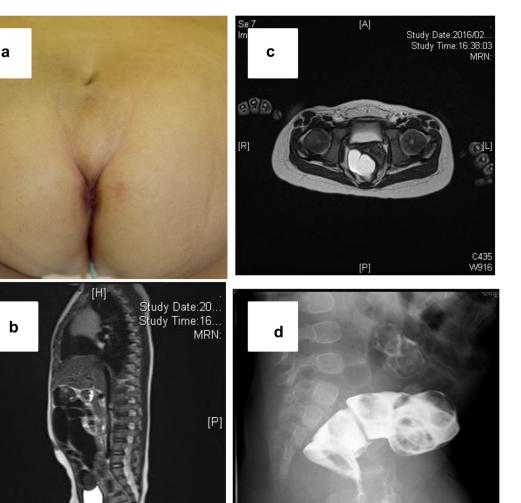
a) A skin dimple was seen at the coccygeal region and a mild bulge was detected around the cranial area of the anus. b) MRI imaging. A sagittal section showed a hyperintensity mass in T2-weighted imaging. The mass was situated in the presacral and postrectal area. c) MRI imaging. A cross section showed a multilocular cyst at the presacral area which was slightly deviated to the right side. d) Barium enema showed a presacral mass that compressed the rectum.
